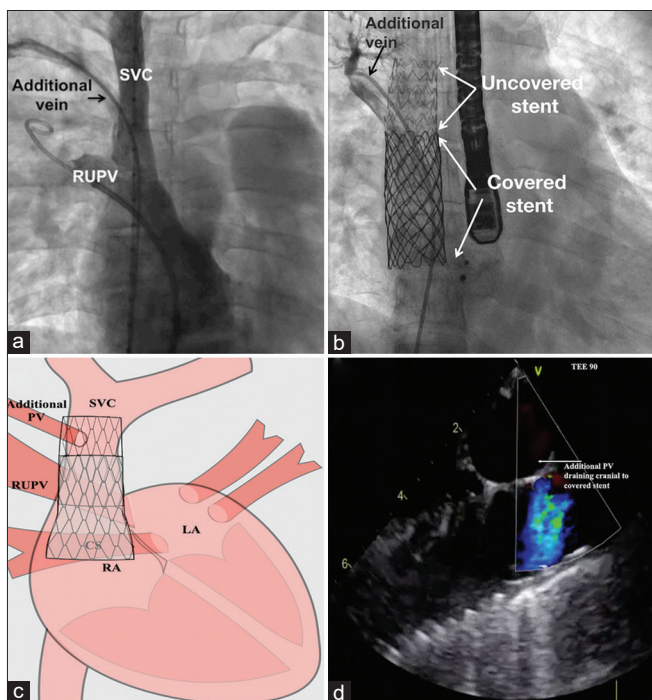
The main right upper pulmonary vein and additional small vein are cannulated separately (a) during an angiogram of the superior vena cava (SVC). A covered stent is deployed caudal to the additional vein to prevent its occlusion and its persistent drainage to the SVC (b), but an uncovered stent is overlapped at the upper end to provide an anchor (c). A bicaval view of the transesophageal echocardiogram (d) shows the flows from the additional pulmonary vein very high in the SVC. RUPV: Right upper pulmonary vein, SVC: Superior vena cava, RA: Right atrium, LA: Left atrium, PV: Pulmonary vein
